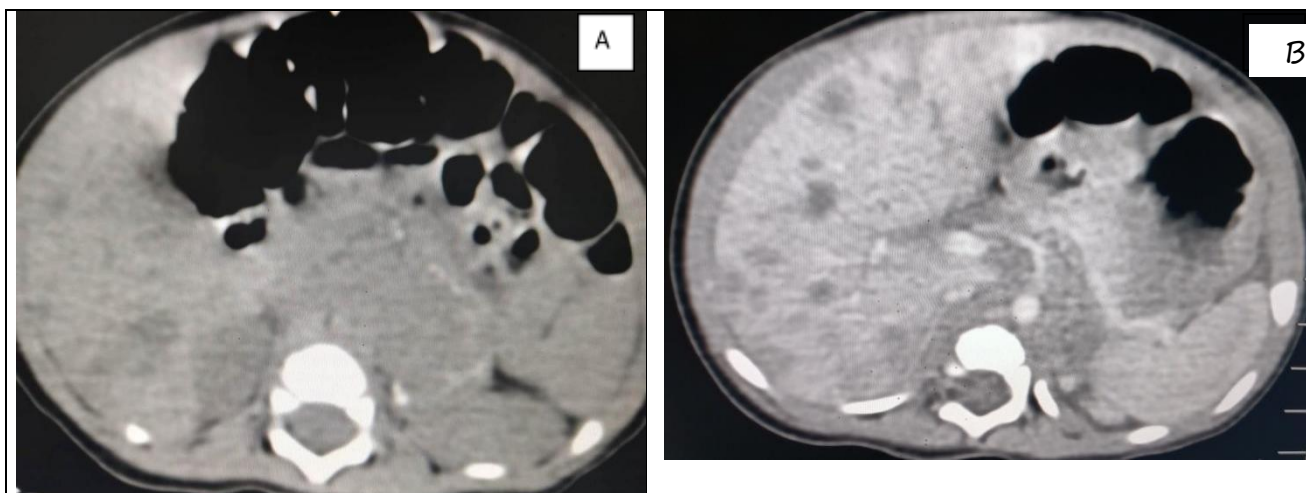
A)Axial plain CT abdomen B) axial contrast CT abdomen showing heterogeneous mass with calcifications in left adrenal region crossing the midline – neuroblastoma and minimally enhancing multiple hypodense lesions in liver – metastasis.
